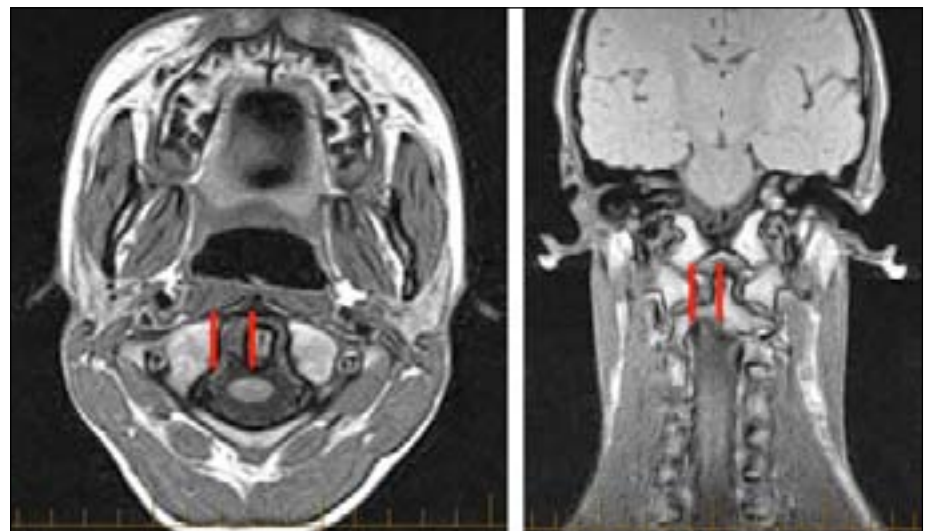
Axial (left) and Coronal (right) CCJ MRI Showing Abnormal Parodontid Spacing
